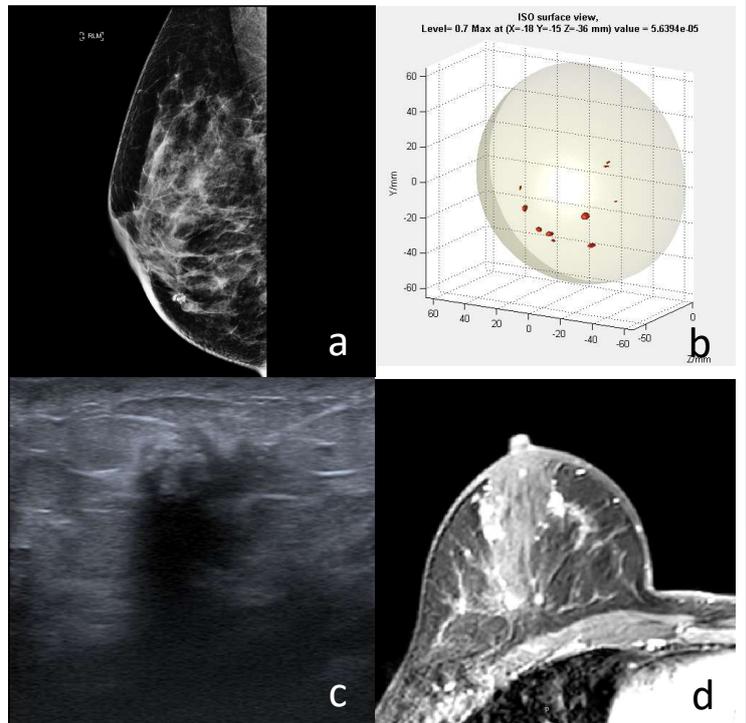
P028 Age 38, BIRAD 'c' Right (a) MMG showing ill-defined distortion with coarse calcification (b) MARIA showing multiple foci throughout lower half of breast (c) Initial US showing only an ill-defined region of concern (d) Gadolinium-enhanced MRI showing more than 10 lesions corresponding to grade 2 invasive ductal carcinoma with mixed pattern of growth accompanied by microcalcifications, high nuclear grade solid and micropapillary DCIS.
